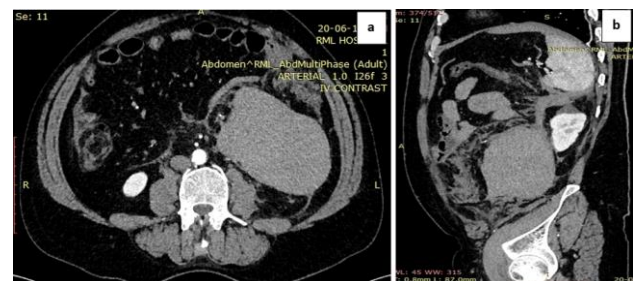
a) and b) Patient with stab injury right flank: axial and sagittal CT of a large retroperitoneal haematoma in right pararenal space displacing descending colon.
